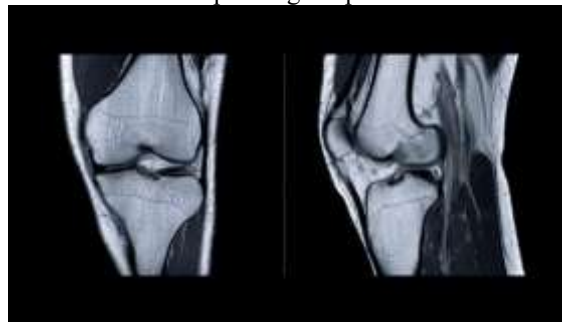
MRI of the knee showing complete disruption of anterior cruciate ligament fibers with increased signal intensity suggestive of complete ACL tear.
